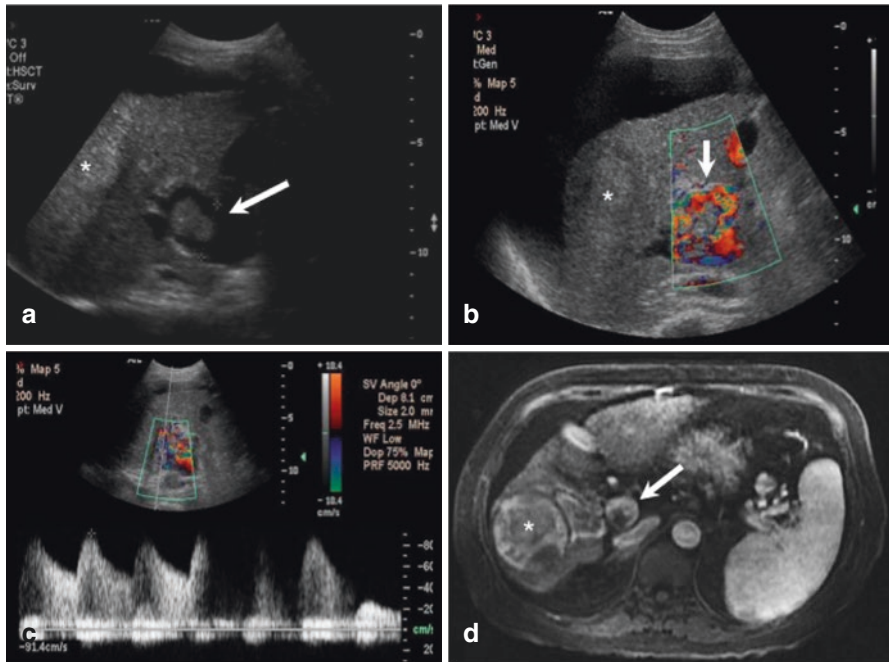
Tumor thrombus of the portal vein (arrows) on B-mode US (a), color Doppler (b), and pulsed Doppler (c), which show isoechogenic content partially filling the lumen of the vein, with arterial low-resistance flow within. Post-contrast MRI phase (d) shows the same findings: hepatocarcinoma (*) and the tumor thrombus (arrow) in the portal vein
